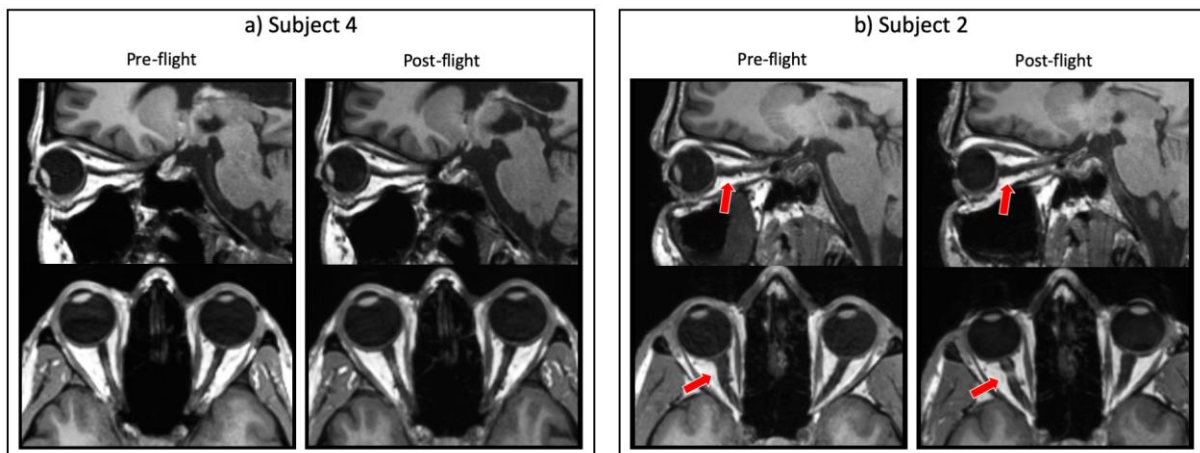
Sample MRI used for ON tortuosity quantification. Launch (pre-flight) and R+1/3 (post-flight) T1-weighted sagittal MRI of two astronauts showing ON a) without and b) with tortuosity after spaceflight. Arrows highlight ON kink location.
